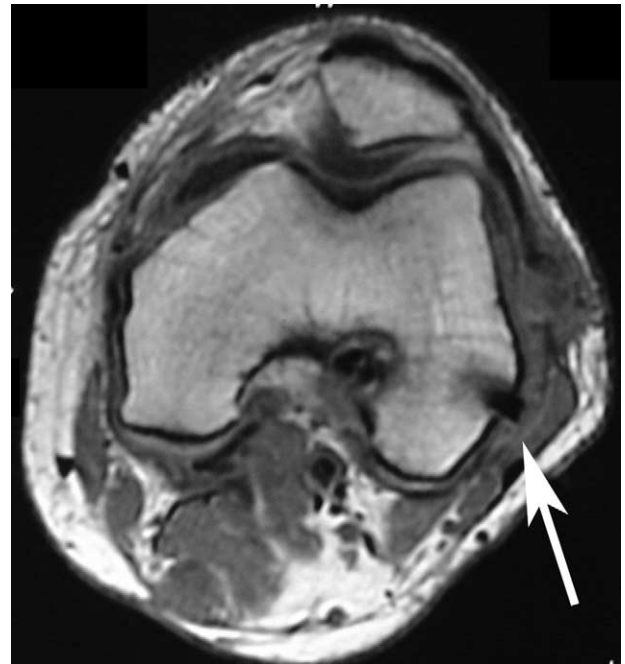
Axial magnetic resonance imaging view of the distal femur showing the femoral cross-pin left proud laterally (arrow), requiring reoperation for lateral knee pain.
